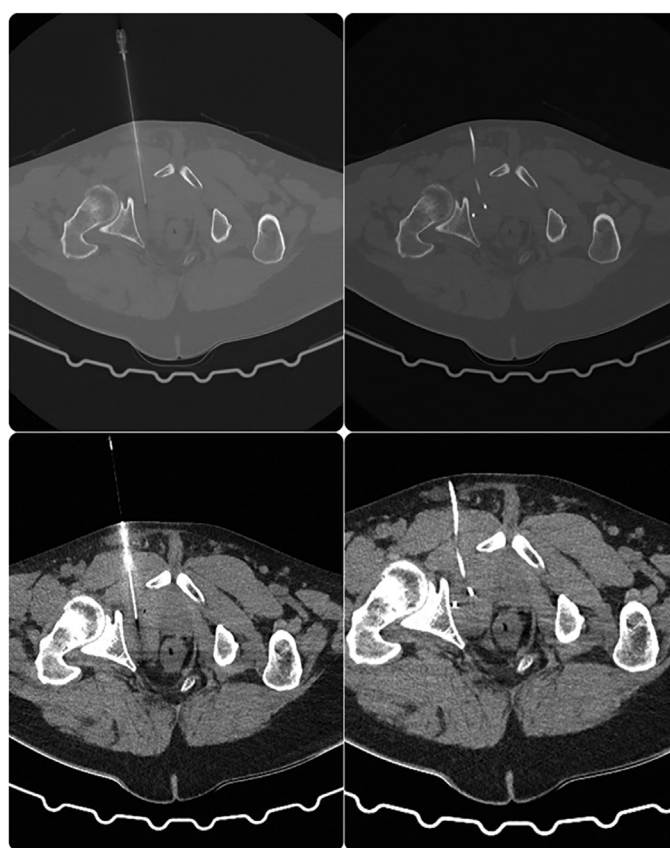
Aspiration of the infected cyst using a 6 Fr catheter under computed tomography guidance
